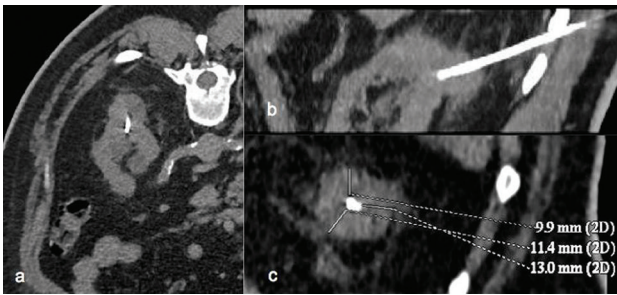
1a) Non-contrast CT scan in prone position. An RFA probe in inserted in the middle of a 3.3 cm exophytic lesion of the left kidney. 1b and 1c) Sagittal and coronal reformats are used to delineate the exact position of the lesion in comparison to the margins of the lesion prior to ablation
